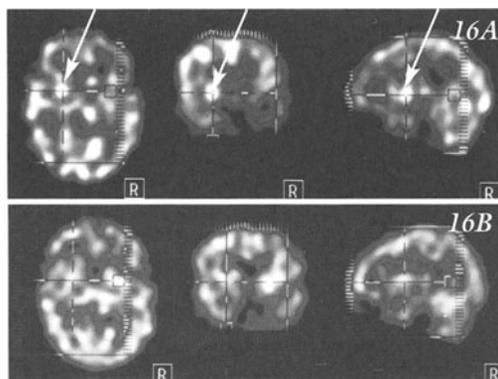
SPECT: Areas of increased perfusion during seizure activity are indicated in this scan. A) ictal uptake in areas of right temporal parietal and frontal lobes B) interictal. This 3-year-old child initially had infantile spasms with an EEG pattern consistent with the disorder hypsarrhythmia. Subsequently the EEG abnormalities were right anterior quadrant or parietal. Courtesy of Dr. Paul Marshall Pediatric Neurology University of Massachusetts.
